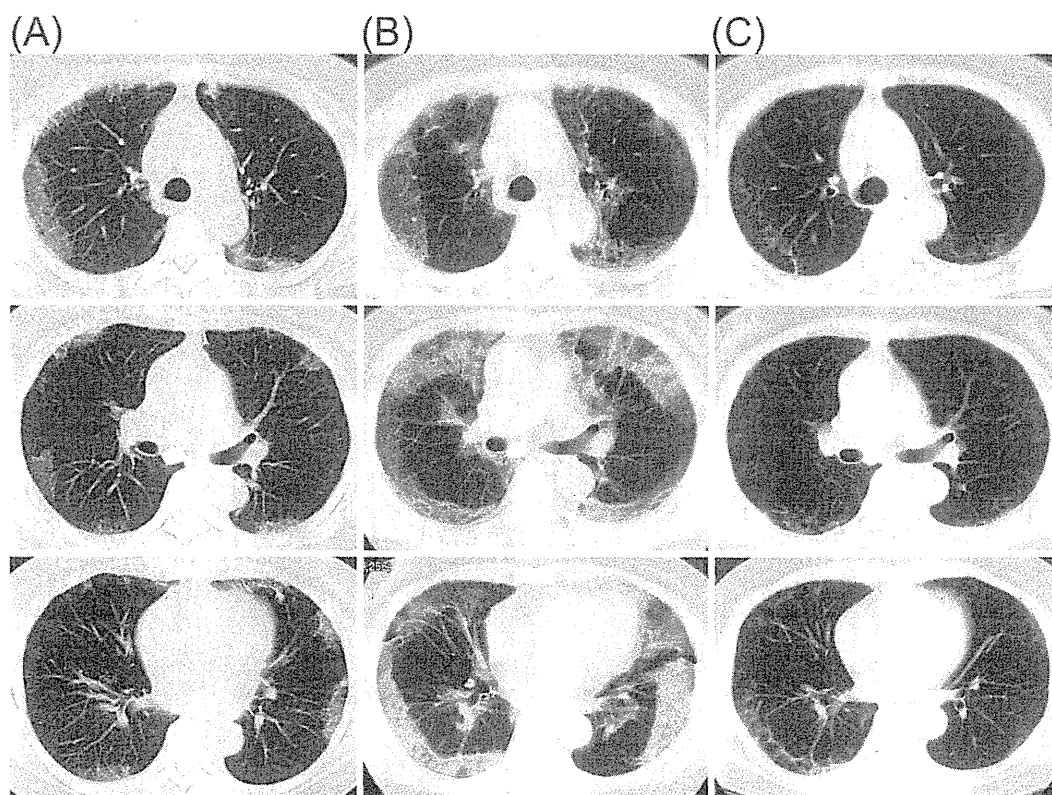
Chest computed tomography (CT) revealed peripheral ground-glass opacities (A), which worsened after oral prednisolone and cyclosporine regime (B) and improved markedly after 6-month GM-CSF inhalation therapy (C).
